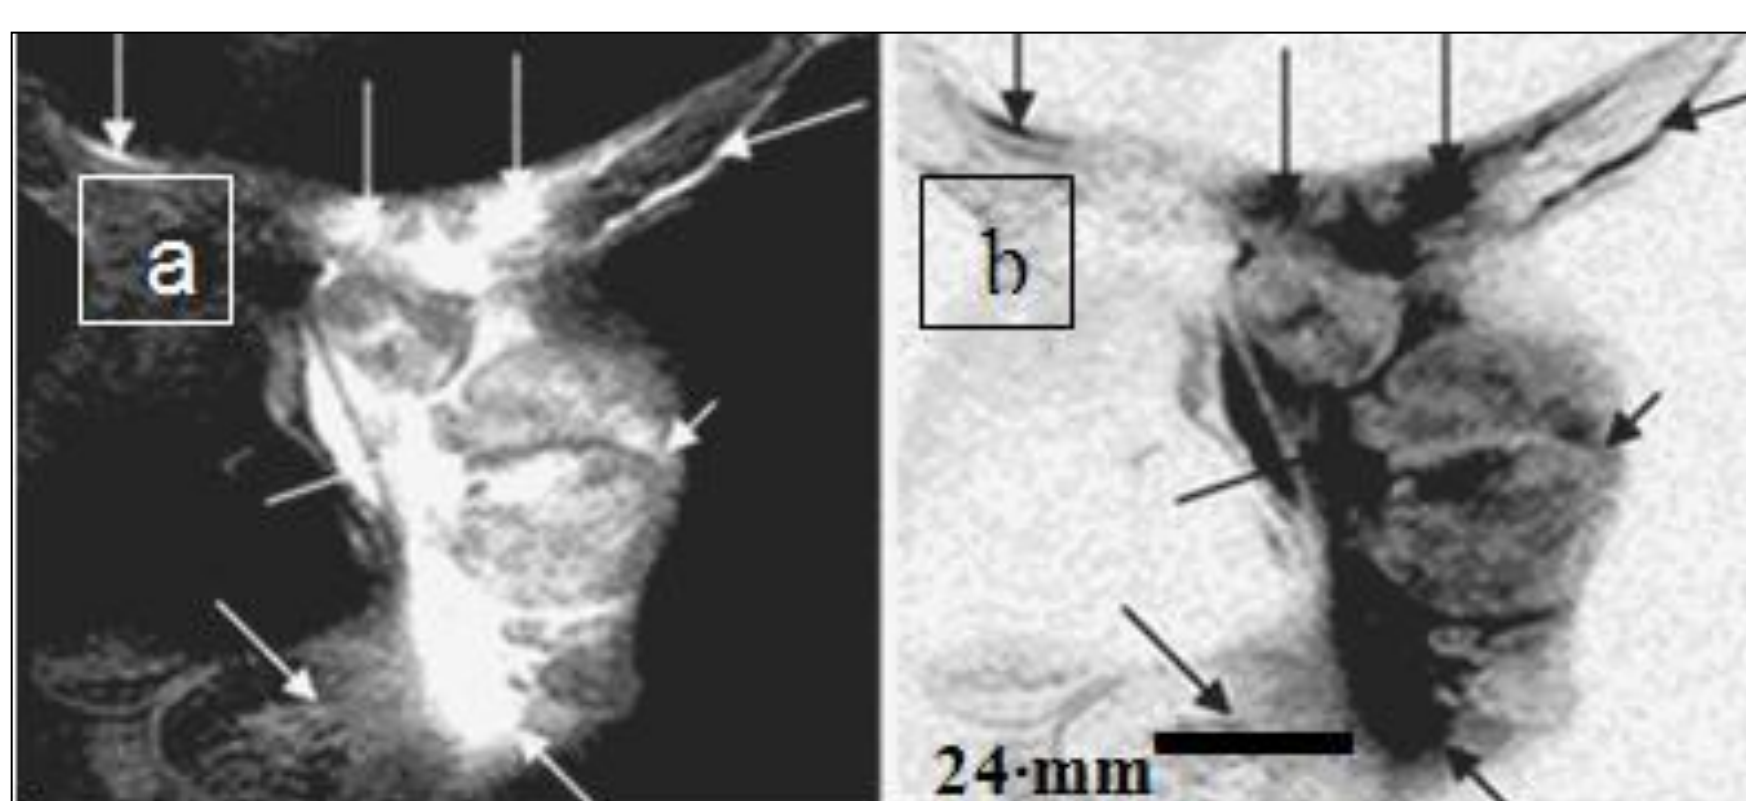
(a, b). MRI-monitoring of globular form Ca 755: (a) an invasion of cells in lymphatic system and other normal tissues (white arrows); (b) negative tumors - as inverse spots.
